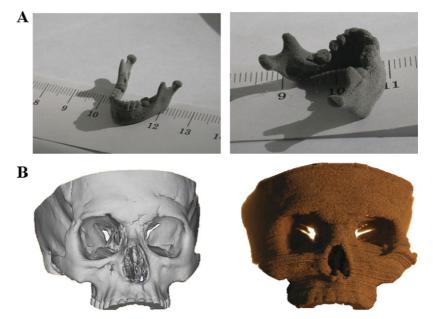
Use of the SSLS scaffold manufacturing procedure to produce custom scaffold shapes. Jaw structure (A) and skull structure (B) produced from corresponding MRI scan. Figure kindly provided by Dr V. K. Popov, Institute of Laser and Information Technologies, Russian Academy of Sciences.
